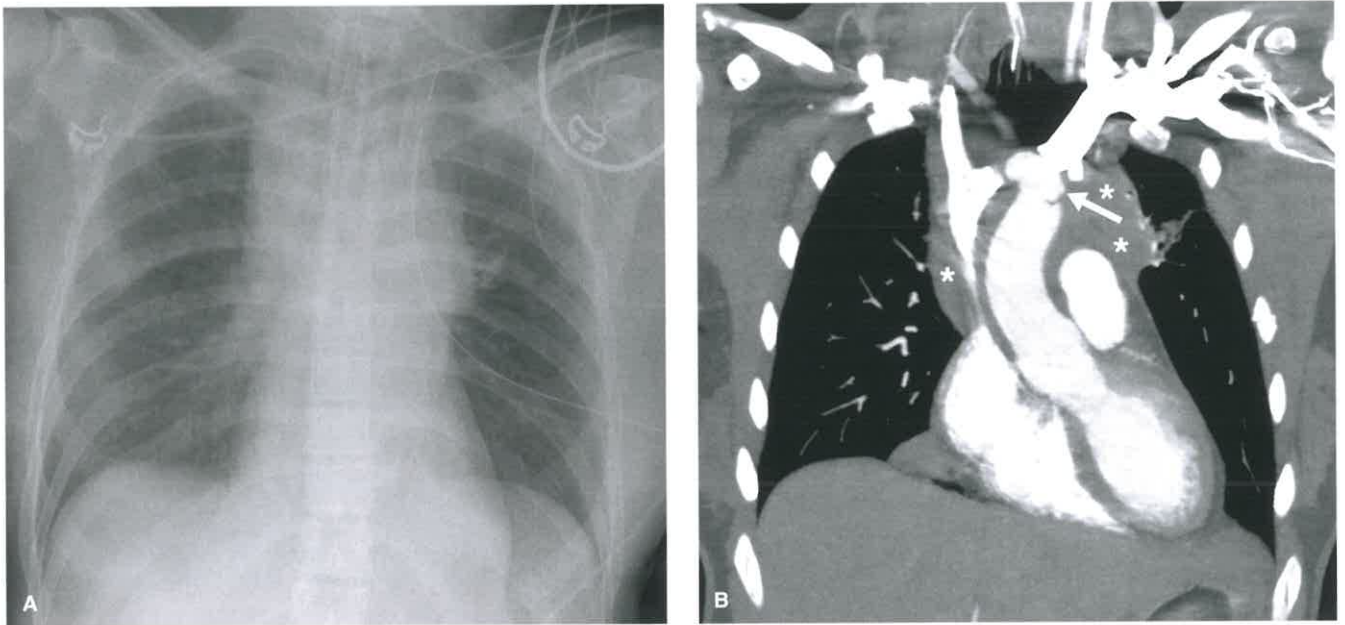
Mediastinal Hematoma From Traumatic Aortic Injury. A: Portable chest radiograph in a 38-year-old woman involved in a motor vehicle accident demonstrates a widened mediastinum. B: Coronal maximum intensity projection CT aortogram demonstrates a traumatic pseudoaneurysm of the aortic arch (*arrow*) with extensive mediastinal hematoma (*asterisks*).
